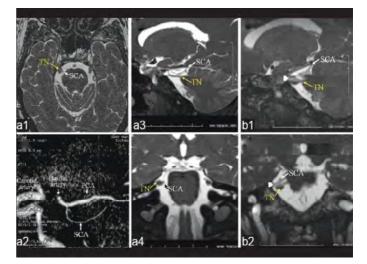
Preoperative (a) and postoperative (b) 3D FIESTA and 3D TOF MOTSA MRI scans. (a1) Transverse 3D FIESTA image at the level of pons. The small rounded structure medial to the trigeminal nerve (TN) corresponds to the right superior cerebellar artery (SCA). (a2) The SCA loop can be easily identified on the sagittal reformatted 3D TOF MOTSA image. Sagittal (a3) and coronal (a4) reformatted 3D FIESTA images demonstrate rostral-medial compression of the TN by the SCA loop. Postoperative sagittal (b1) and coronal (b2) reformatted 3D FIESTA images reveal the proper position of the Teflon implant (white arrowhead) between the SCA and the TN. PCA, posterior cerebral artery
